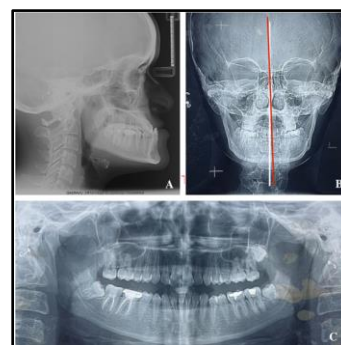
(A) Pre-treatment lateral cephalogram; (B) Pre-Treatment Pa Cephalogram Showing Mild Deviation Of Chin Towards Left Side (Red Color); (C) Pre-Treatment Orthopantomogram
